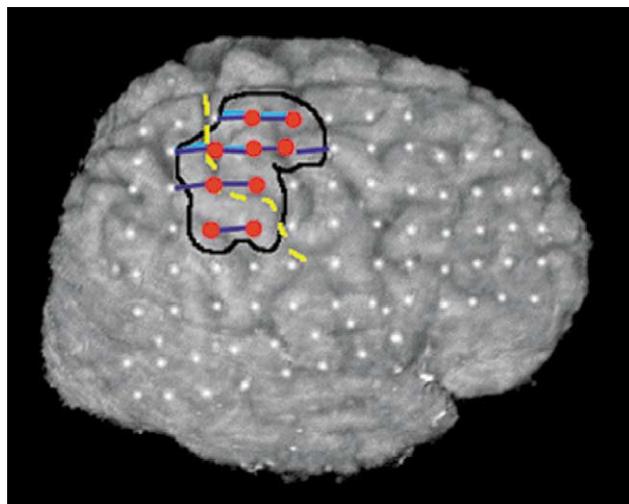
Surface reconstruction of right hemisphere, using high-resolution MRI, co-registered with subdural electrode grid. White circles indicate electrodes tested. Dark blue lines indicate left hand motor stimulation mapping. Light blue lines indicate left arm motor stimulation mapping. Red electrodes indicate seizure focus. Yellow dashes indicate central sulcus. Black line surrounds transected area.
